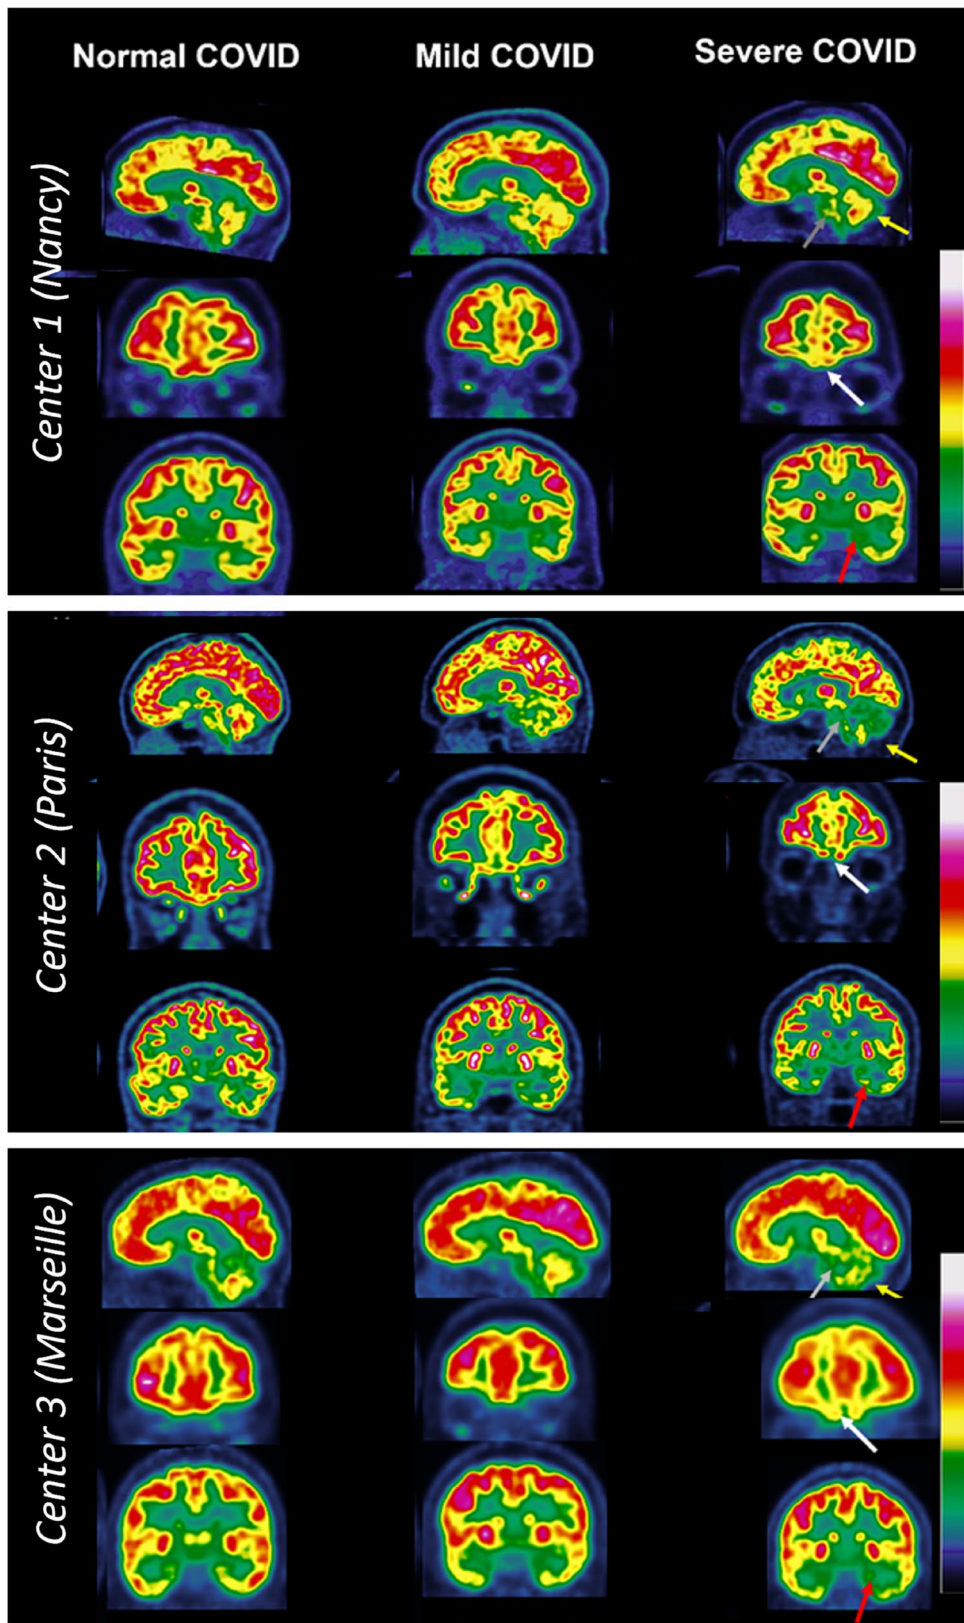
Typical examples of brain ^{18}F -FDG PET images of patients with suspected long COVID in the three French nuclear medicine departments, all presenting positive RT-PCR and/or serology tests (cases from Nancy in the upper part, Paris in the middle part and Marseille in the lower part of the figure). Patients included in the left column were those with brain ^{18}F -FDG PET images identified as normal by the nuclear physician experts (a 44-year-old woman referred 301 days after COVID infection for the persistence of dyspnoea on exertion and tachycardia without any cardio-pulmonary damage in the upper part; a 35-year-old woman referred 113 days after acute COVID for persistent asthenia, headaches, sleep disturbance, polyarthralgia and memory/concentration impairment in the middle part; and a 50-year-old woman with memory complaints, headaches and anosmia 314 days after infection in the lower part). The middle column includes patients who were classified as presenting a mild-to-moderate long-COVID hypometabolic pattern (a 41-year-old man who presented asthenia, dyspnoea on exertion and cognitive disorder 315 days after acute COVID acute infection in the upper part; a 52-year-old woman referred 342 days after COVID infection for cognitive complaints with language and memory difficulties, asthenia, insomnia and muscular weakness in the middle part; and a 55-year-old woman presenting memory complaints, loss of words, headaches and dyspnoea 168 days after the acute stage of the infection in the lower part); and the right column includes patients who were classified as presenting a severe long-COVID hypometabolic pattern (a 37-year-old-woman presenting cognitive impairment, dyspnoea, orthostatic hypotension, hypersomnia and fever at 253 days since symptom onset in the upper part; a 38-year-old-woman referred for brain ^{18}F -FDG PET 545 days after acute COVID infection, with dysexecutive symptoms, memory difficulties, dizziness, limb paraesthesia, asthenia, myalgia and polyarthralgia in the middle part; and a 20-year-old-woman with persistence of functional symptoms, with asthenia, headaches and memory/concentration impairment 170 days after infection in the lower part). In these patients with a typical severe long-COVID hypometabolic pattern, the brain areas with hypometabolism are identified with arrows: white arrows for the fronto-orbital olfactory regions, red arrows for the other limbic/paralimbic regions, grey arrows for the pons and yellow arrows for the cerebellum
